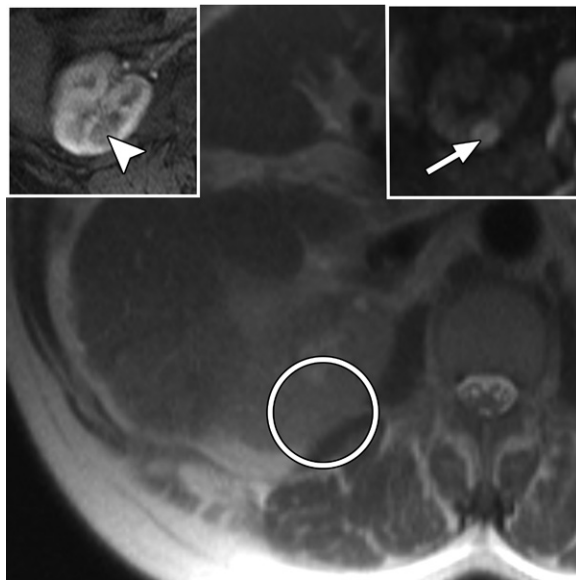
Greater conspicuity of a renal mass with DWI in an 82-year-old woman who underwent liver MRI for cirrhosis. Axial T2-weighted MR image does not show any renal cortical abnormality (circle). Diffusion-weighted image (right inset) shows a rounded hyperintensity (arrow) corresponding to a hypoenhancing mass (arrowhead) on the T1-weighted arterial phase MR image (left inset), which may be easily overlooked with other sequences but is highly conspicuous with DWI.
